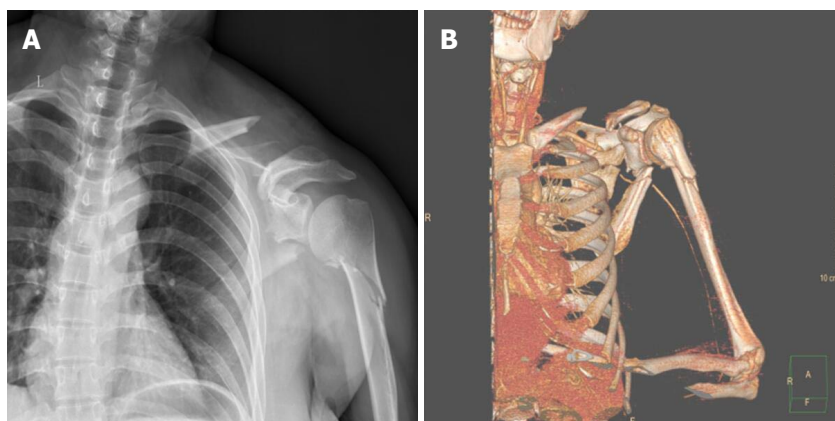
Plain anterior-posterior radiograph and computed tomography image of the left shoulder. A: X-ray demonstrating fractures of the left scapula, left proximal humerus, left clavicle and left shoulder soft tissue swelling; B: 3D computed tomography angiography reconstruction of the left shoulder also demonstrating multiple fractures of the scapular region and interruption of blood flow through the axillary artery.
